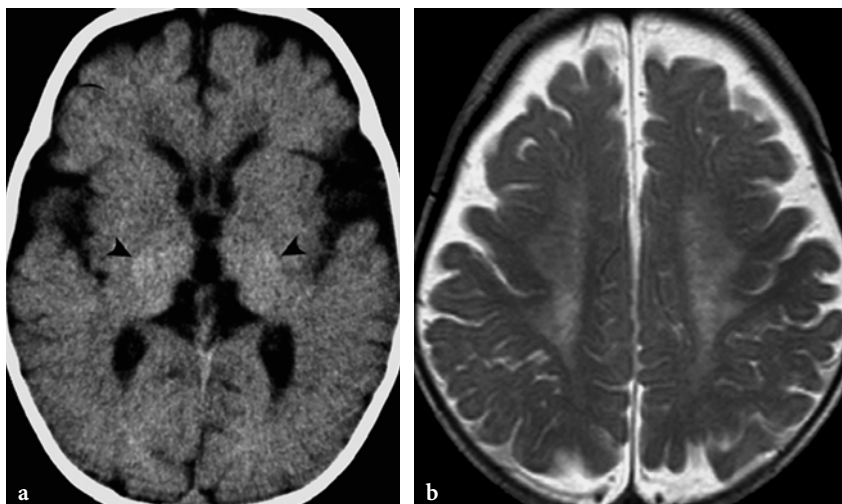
CT and MRI findings in a 7-month-old girl with globoid cell leukodystrophy (Krabbe disease) (case courtesy of Dr. P. Tortori-Donati, Genoa, Italy). a Axial CT scan shows subtle hyperdensity of both thalami, consistent with calcification (arrowheads). b Axial fast spin-echo T2-weighted image shows hyperintense white matter within the centrum semiovale bilaterally. The U fibers appear to be spared in this early disease stage
